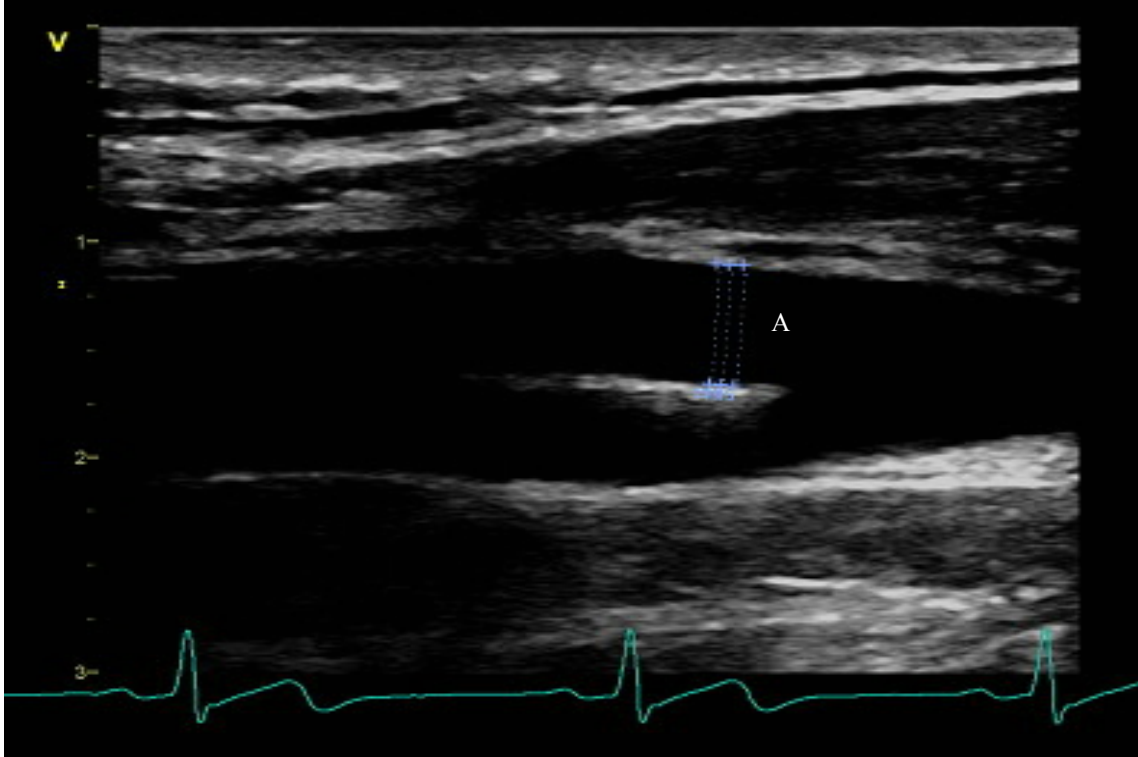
Figure B-2. Longitudinal view of the CCA (common carotid artery) bifurcating into the internal and external carotid arteries using B-mode ultrasonography. Note: diameter measurements were taken at the proximal internal carotid artery using EchoPAC calipers (A).
